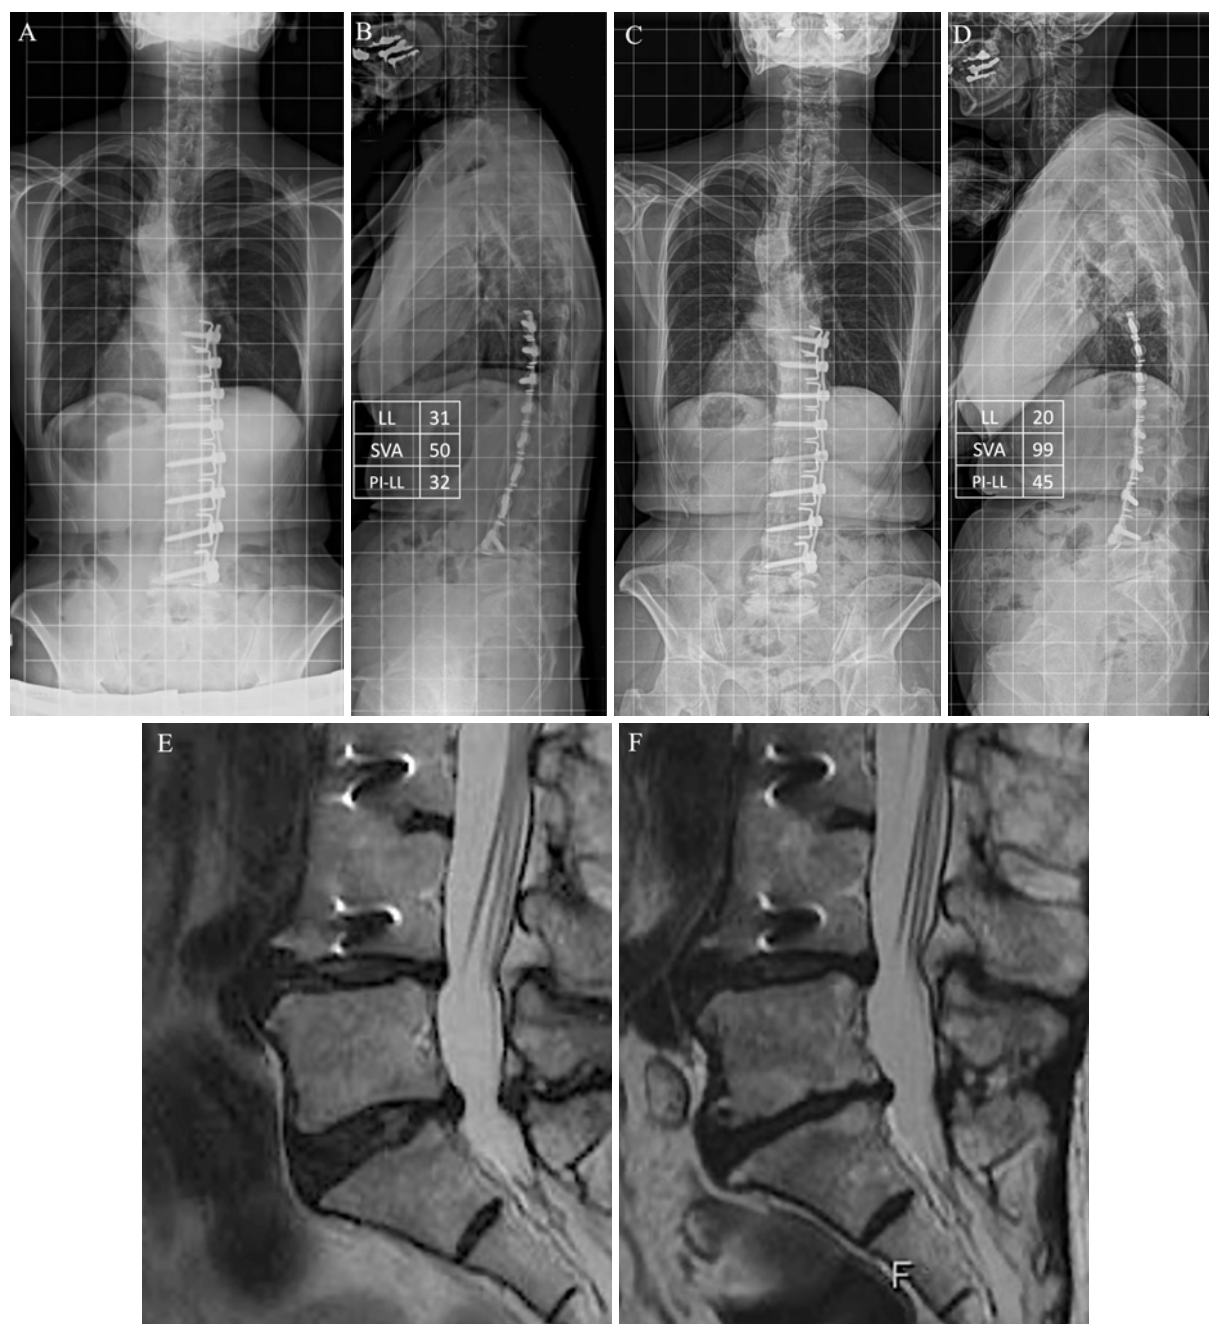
The patient underwent anterior spinal fusion (Dwyer method) from T9 to L4 at the age of 14. Frontal and lateral radiographs (A, B) were taken at the previous (age 51, 37 years postsurgery) and latest surveys (age 58, 44 years postsurgery) (C, D). Sagittal alignment had worsened in the latest survey than in the previous survey. The MRI findings at the previous survey showed a Pfirrmann grade 3 for the L5–S1 disc (E), while at the latest survey, it had progressed to grade 5, indicating advanced intervertebral disc degeneration (F).
